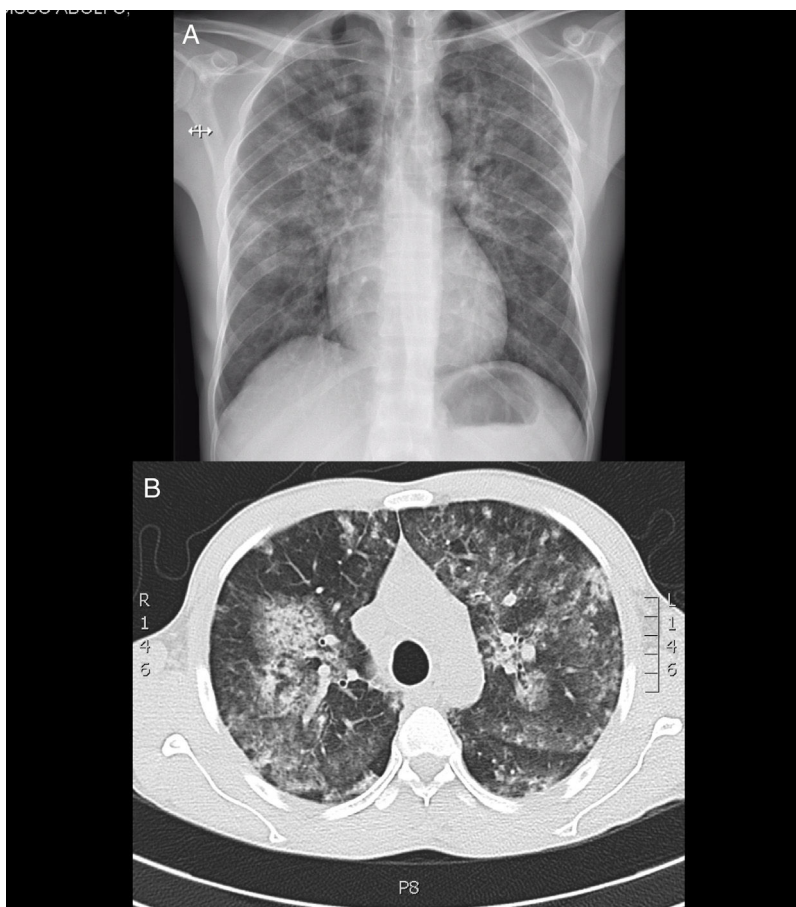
A) Thoracic X-ray showing diffuse infiltrates in both pulmonary fields. B) Generalised mixed opacities observed in high resolution thoracic tomography.
